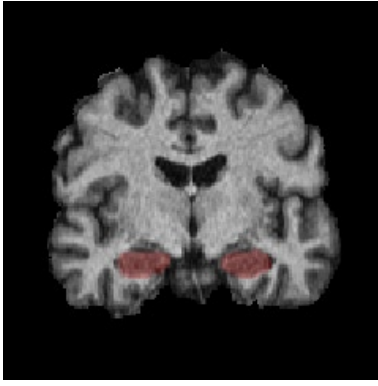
Coronal view of bilateral hippocampal segmentation (red color) superimposed on a T1-weighted image.
